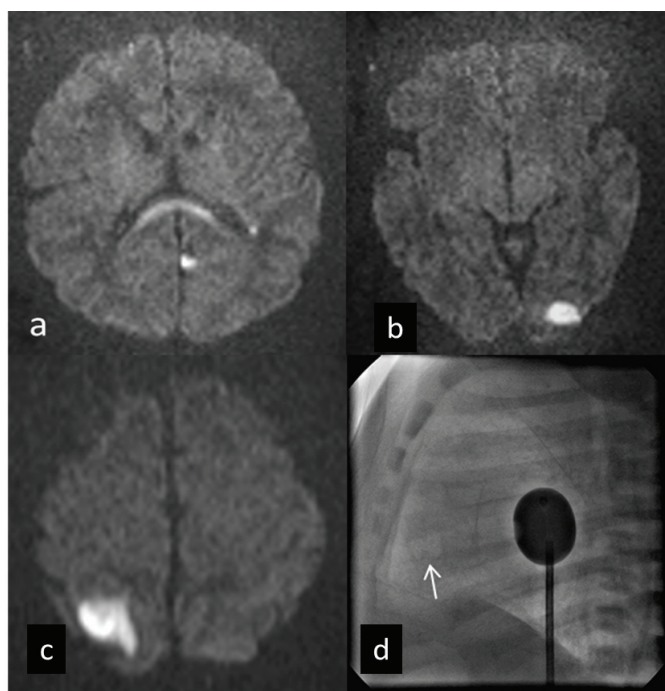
10-days-old newborn with TGA, underwent BAS at the age of 6 days old, brain MRI was performed before ASO. Axial DWI (a, b, c), $b=2000 \text{ sec/mm}^2$, shows multifocal arterial cortical stroke and hypoxic-ischemic WMI. On angiographic image in the projection of the right ventricle air bubbles (arrow) are visualized.
